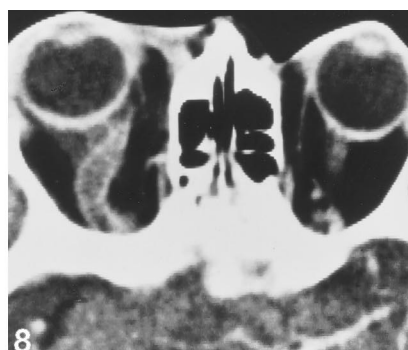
Right-sided exophthalmos in a 67-year-old woman 1 week after onset of bilateral cavernous sinus thrombosis due to right-sided facial phlegmon. Axial contrast-enhanced CT scan shows exophthalmos and extensive thrombus in dilated right superior ophthalmic vein.
